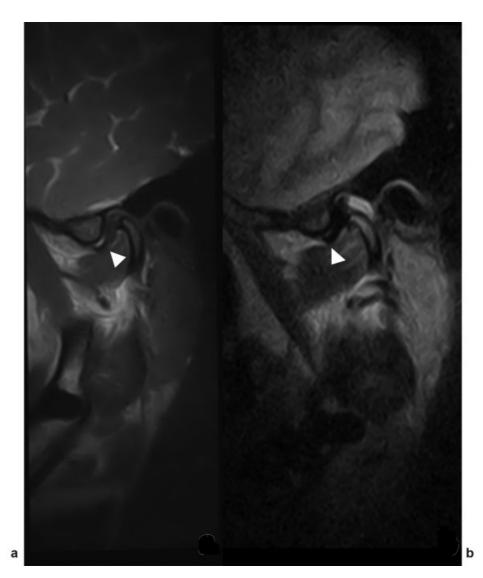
Right temporomandibular joint examination on weight-bearing magnetic resonance imaging (the table is tilted 81 degrees). (a) Sagittal T2-weighted imaging with mouth closed. The articular disk appears displaced anteriorly and mesially (arrowhead). (b) Sagittal T2-weighted imaging with mouth open. The articular disk appears displaced anteriorly and mesially (arrowhead) with limitation to open the mouth; higher amount of intra-articular fluid is present.
